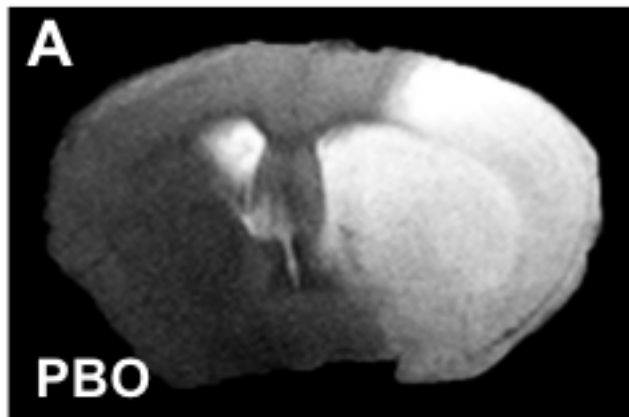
Oral TCT is delivered to brain tissue and attenuates acute ischemic stroke-induced lesion volume. (A) 48h after MCAO, stroke-induced lesion volume was determined by 11.7T MRI and (B) quantified by digital planimetry. TCT supplementation of 10 weeks significantly lowered stroke-induced brain lesion volume as compared to PBO control. Data courtesy of Mallory Heigel and Surya Gnyawali.
